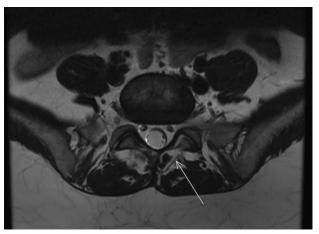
Axial T2-weighted magnetic resonance imaging (MRI)—arrow denotes incomplete formation of the left lamina of L5. There is otherwise no significant disc herniation, central or foraminal stenosis. Sagittal T2 + fat-saturated MRI—no tethering, significant disc degeneration, herniations, or other concerning findings are noted.
